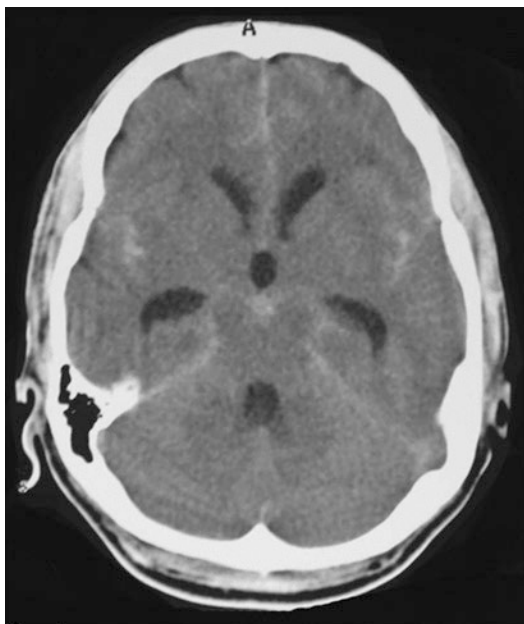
Axial non-contrast CT scans showing *normal* ventricles and *early* hydrocephalus in a 48 year old female school teacher who gave a 24-h history of sudden severe headache. She had neck stiffness and had vomited twice. The early hydrocephalus is much more easily visible than the increased hyperdensity in the right sylvian fissure and interhemispheric fissure and right ambient cisterns. In the more severe and *late* case of hydrocephalus following SAH, the temporal horns are larger and the third ventricle is rounded with obvious residual SAH visible in the usual locations bilaterally
